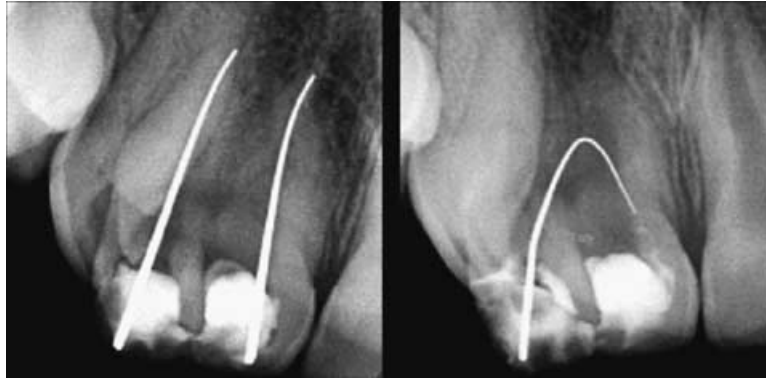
Radiographs using silver points to determine the length of the root preparation and to localize the midroot connection.
